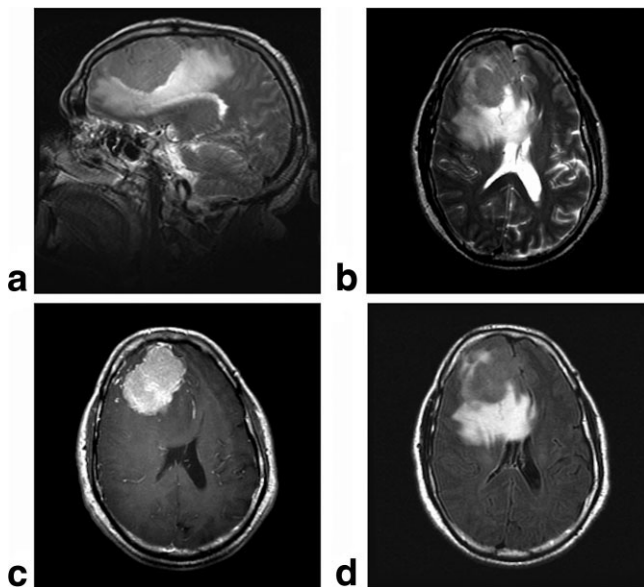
Anatomy: edema. Anatomical images of a patient with a large tumor in the frontal lobe, surrounded by a large space-occupying edema. The extent of the lesion is seen in a mid-sagittal  $T_2$  image (a) and in an axial slice (b) coregistered with the diffusion data. The extent of the tumor is best viewed in a gadolinium-enhanced  $T_1$  image (c), while the edema is best viewed with a  $T_2$ -FLAIR image (d).
